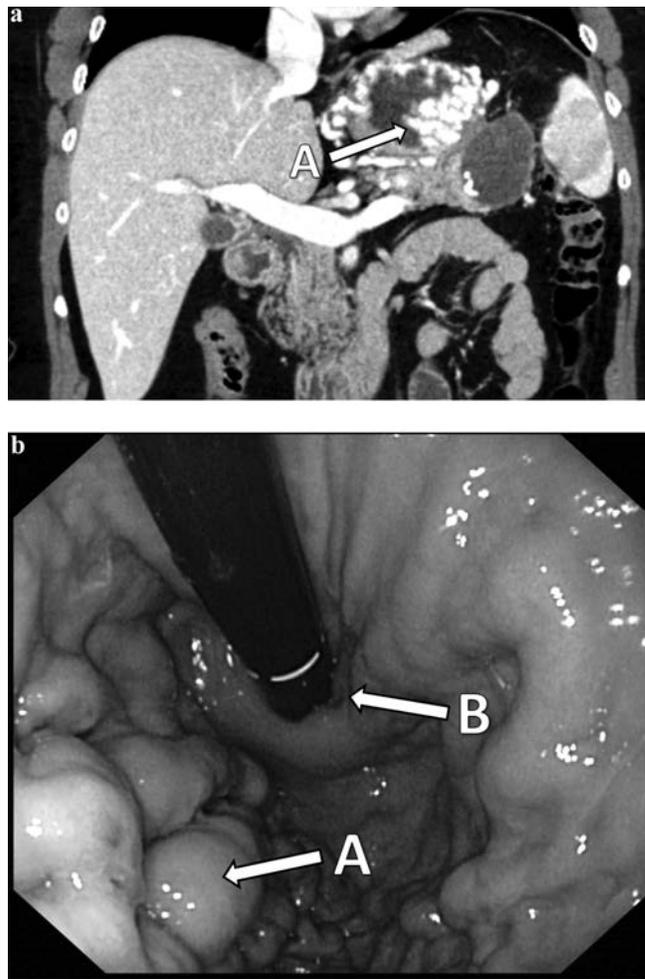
a, Abdominal CT scan before splenic artery embolization. (A, gastric varices.) b, Gastroscopy before splenic artery embolization. (A, gastric fundal varices; B, endoscope at cardia.)
